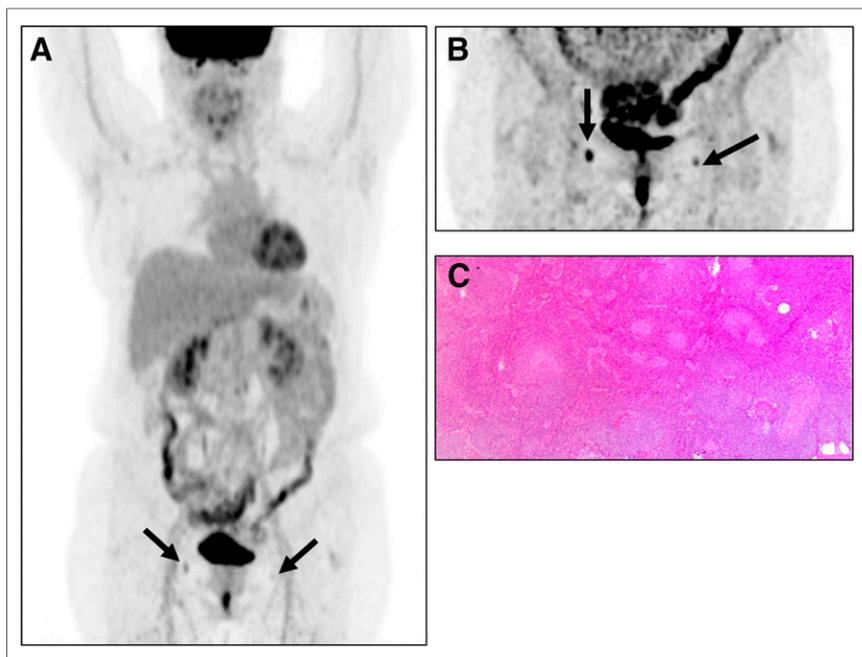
A 60-y-old woman with midline tumor. (A) Maximum-intensity projection of standard ^{18}F -FDG PET/CT image showing focal uptake in right groin (SUV_{max} , 3.5) as well as in left groin (SUV_{max} , 2) (arrows). (B) Maximum-intensity projection of delayed scan showing increase of focal uptake in right groin (SUV_{max} , 6.39) and in left groin (SUV_{max} , 3.41) (arrows). (C) Pathologic examination showed no metastatic LNs in either groin.
